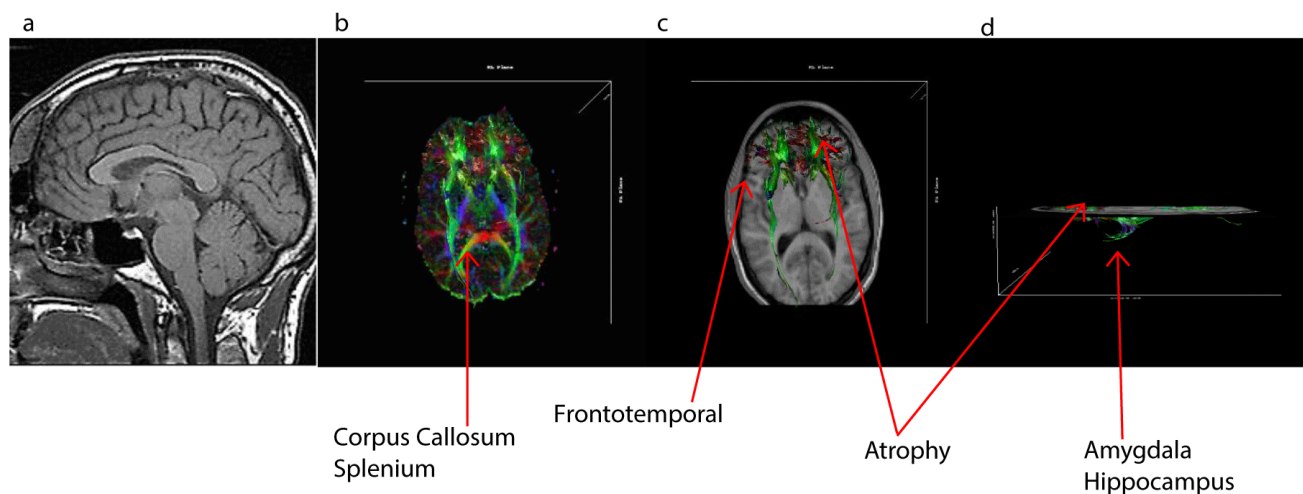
Male with Co-Occurring Disorders, (a) Sagittal MRI, (b) Axial Whole Brain DTI Slice #15, (c) Axial Slice Frontotemporal Tractography, (d) 3D Transverse View:a, b, c
